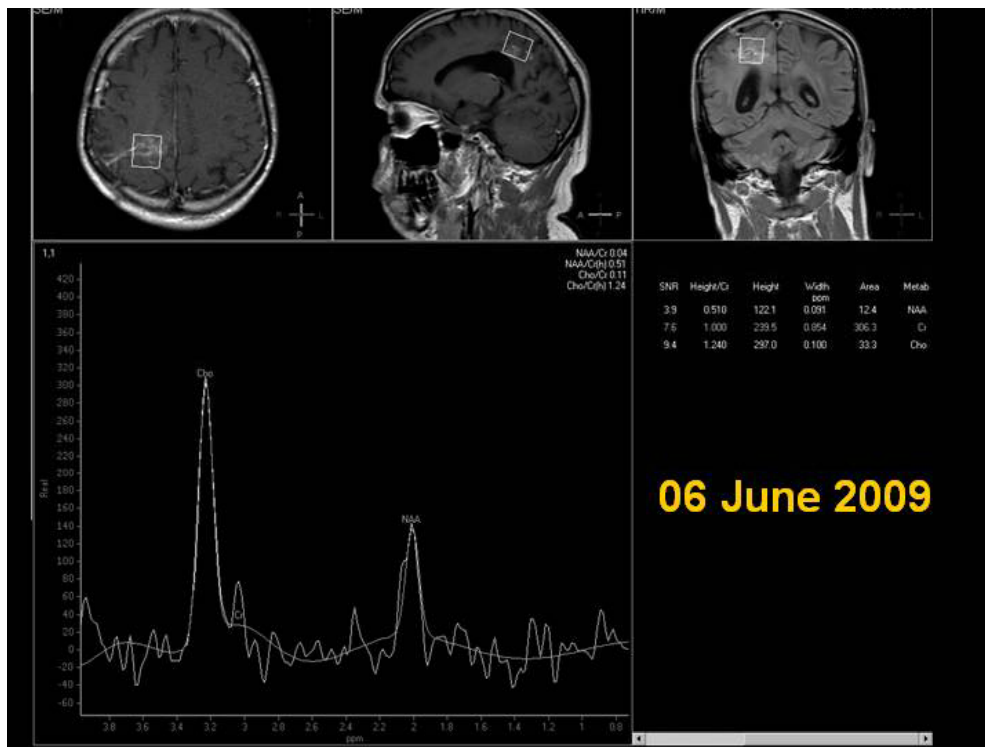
MRS reveals marked reduction in NAA and increased Cho/cr ratio suggesting reactive changes ; suggested follow up MRI with MRS
